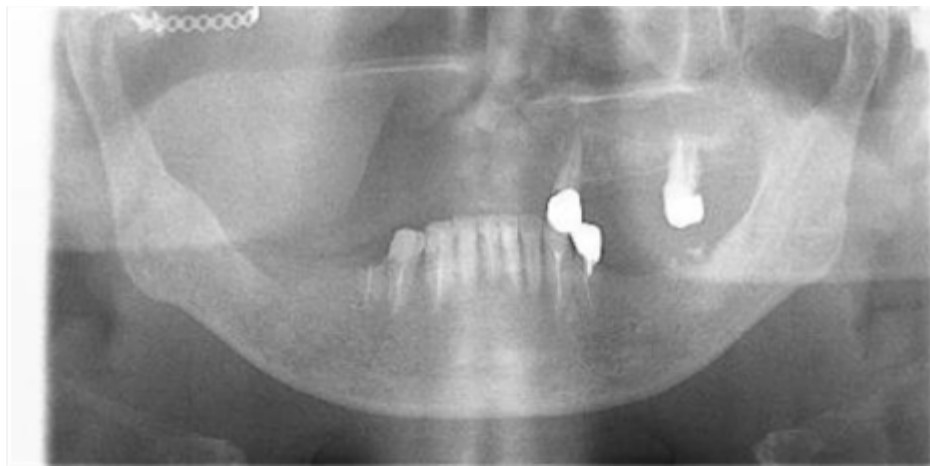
Panoramic radiograph taken 4 years after surgery.
